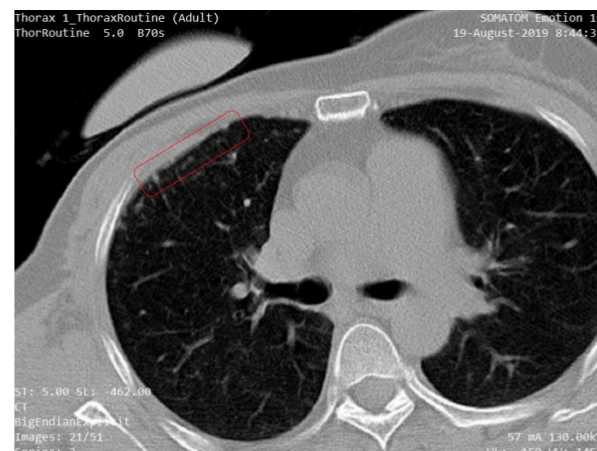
CT scans of RP of a patient with breast cancer three months post radiation therapy.
